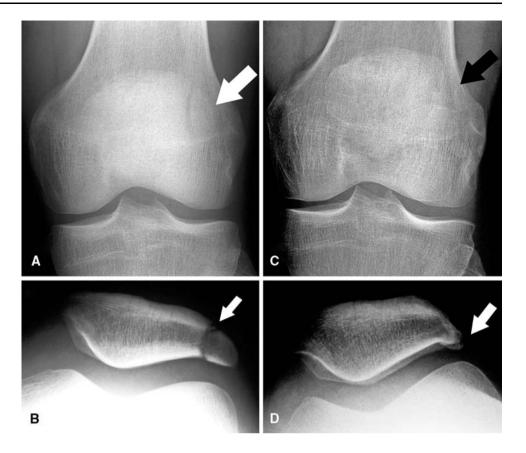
A 22-year-old recruit (Patient 22) first presented with hemarthrosis after a contusion to the knee. At arthroscopy, a lateral bipartite fragment was detected, and as symptoms continued, the fragment was removed 4 months later. The lateral bipartite patellar fragment (arrow) of the left knee was visible on the preoperative (A) anteroposterior and (B) tunnel view radiographs. At final followup 14 years later, the patient had an excellent functional outcome, and the site of excision was not conspicuous on (C) anteroposterior and (D) tunnel view radiographs.
